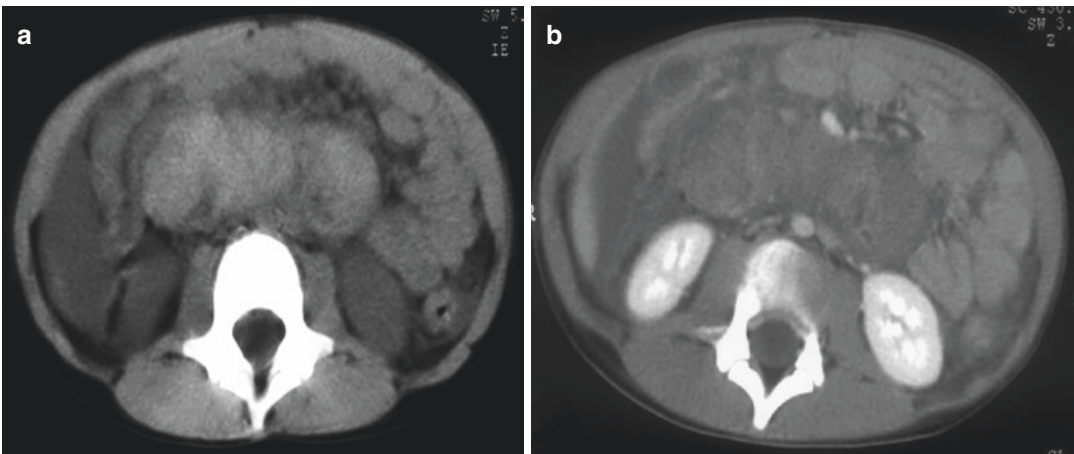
Seven-year-old-girl presenting acute abdominal pain and vomiting. HSP revealed by a hematoma of the wall of third duodenum. (a) CT without contrast
